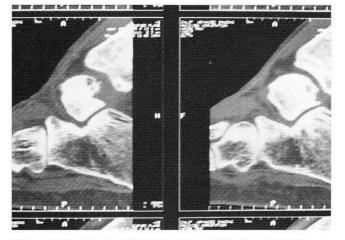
CT scans confirm this unique posterior-lateral position.
